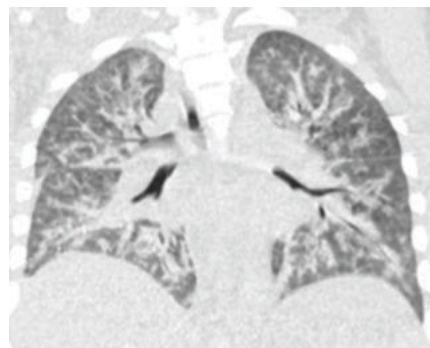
HRCT thorax of the same patient reveals patchy ground glass opacities, ill defined nodules and consolidation which are peribronchovascular in distribution and involving basal segments more, consistent with the findings of pulmonary haemorrhage.
